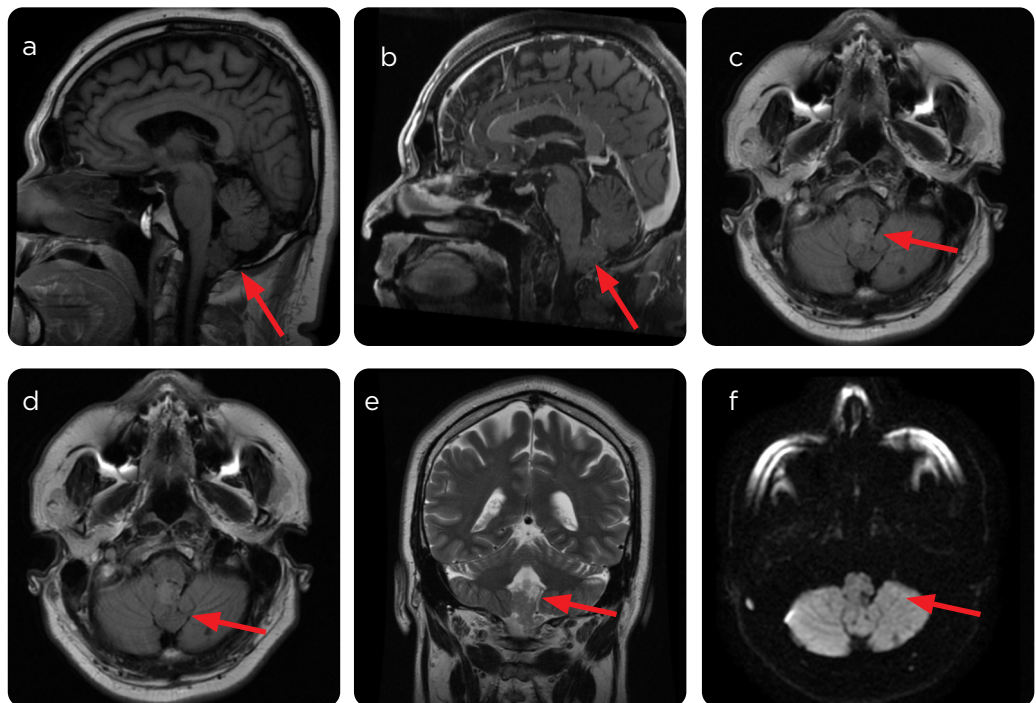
Subependymoma of the inferior medullary leaflet of the fourth ventricle. a) MRI with T1 information: intermediate signal lesion. b) With contrast medium: low enhancement. c and d) FLAIR sequence; and e) Spin echo with T2 information: discretely high signal. e) Diffusion sequence: no restriction to water diffusion.
